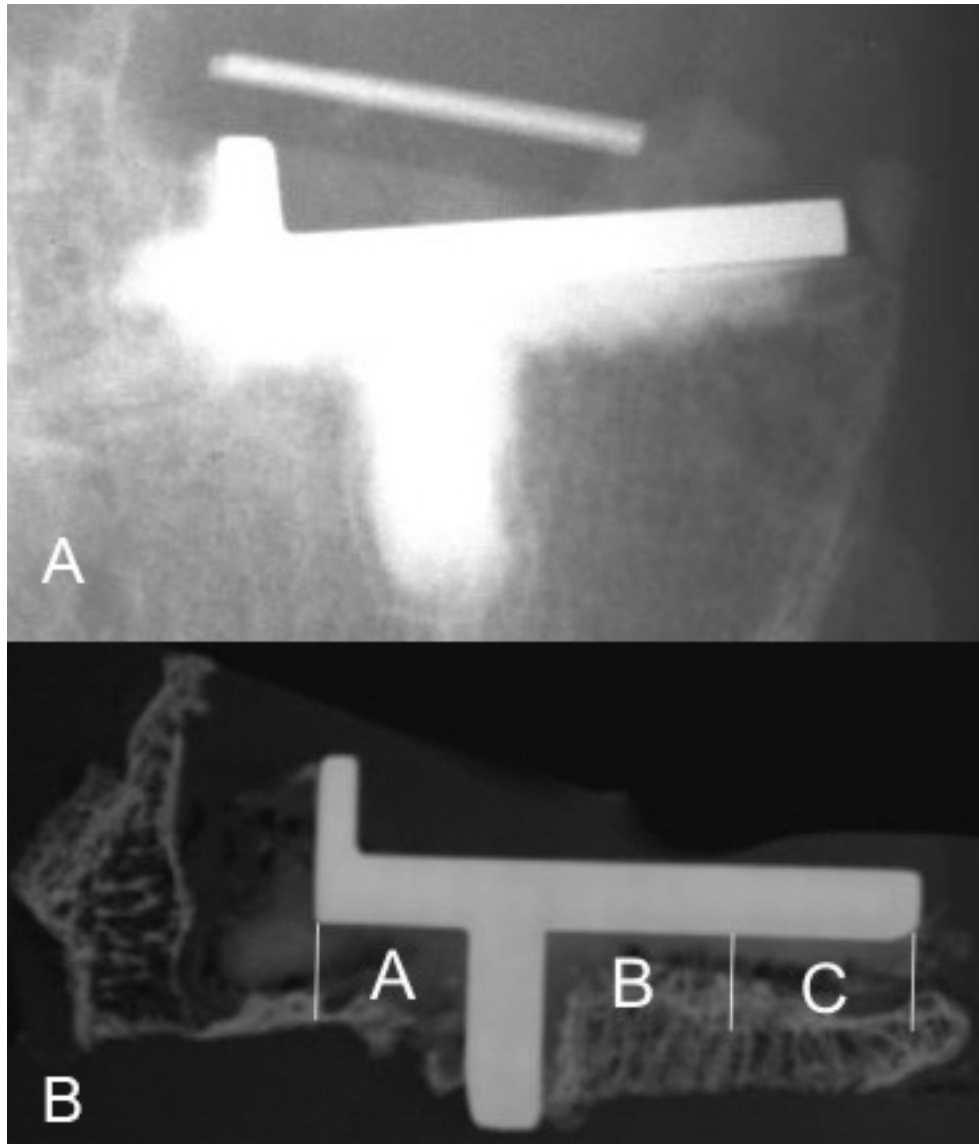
The pre-revision radiograph for a patient revised for mobile bearing dislocation. Figure 2-1B A section radiograph, of the same patient after retrieval and preparation of the tibial component, for assessment of radiolucency, with three regions: lateral to the keel (A), medial to the keel (B) and far medial (C). Medial and lateral descriptions were reversed for lateral compartment samples.
